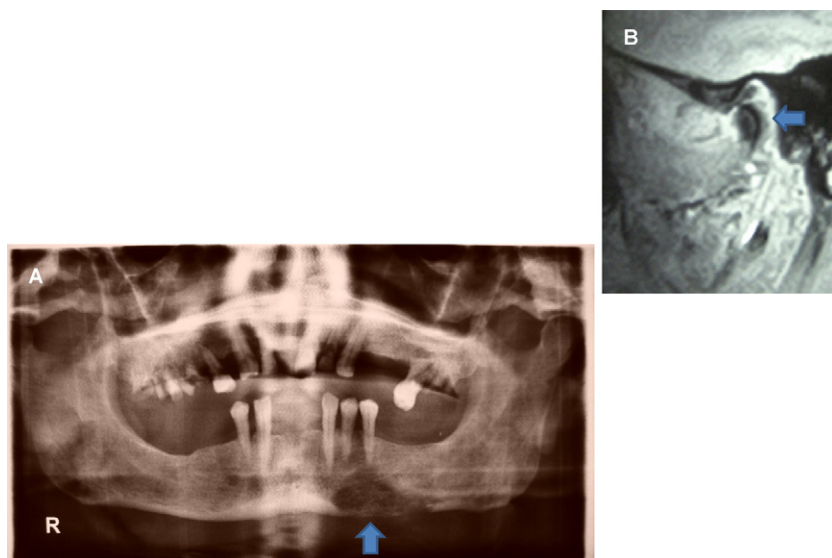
(A) Panoramic radiograph showing a radiolucent area underlying and posterior to teeth No. 33, 34 and 35, with basal mandibular erosion. (B) Sagittal MRI demonstrating the osteolytic lesion in the left mandibular condyle. There was no extraosseous infiltration.
